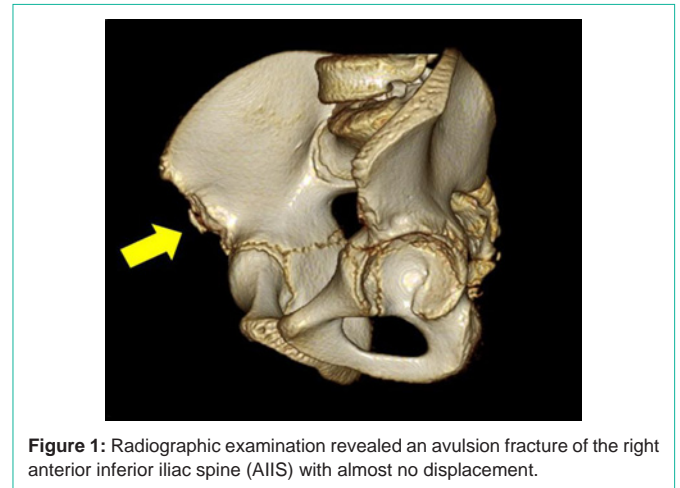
Radiographic examination revealed an avulsion fracture of the right anterior inferior iliac spine (AIIS) with almost no displacement.
